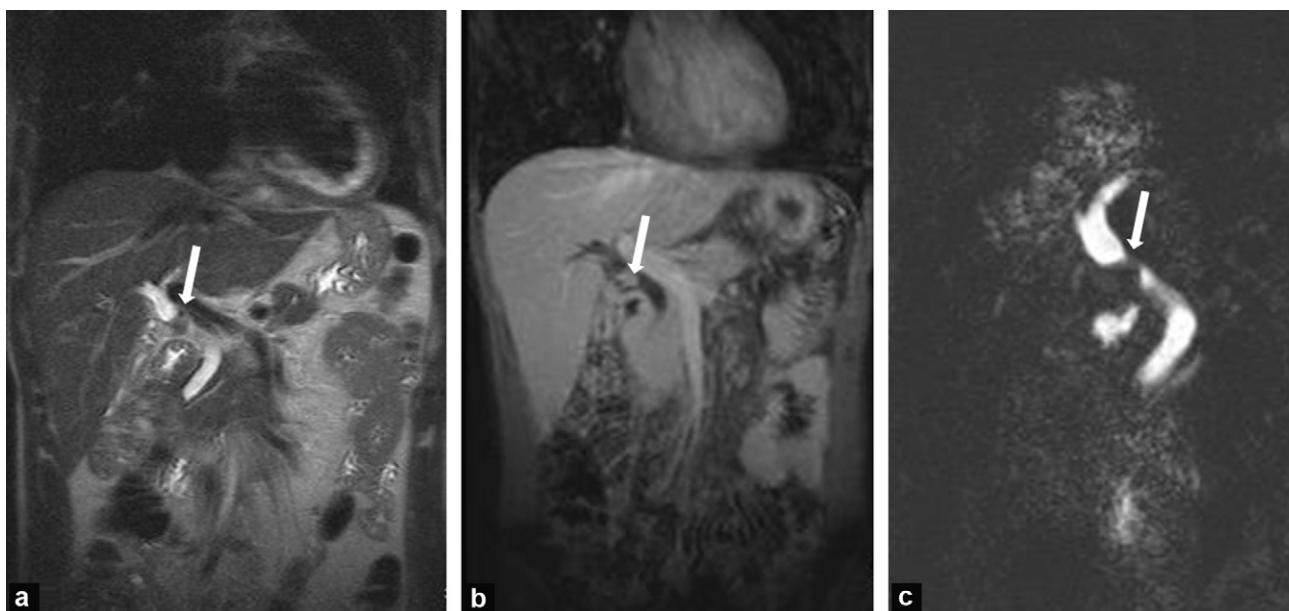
MRCP. Coronal images with T2-weighting (a), T1-weighting after injection of gadolinium chelates (b) and T2-weighted 3D MRCP (c). Intrabiliary duct tumour, hypointense in T2-weighting, isointense in T1C+, responsible for eccentric asymmetric stenosis of the proximal common bile duct.
